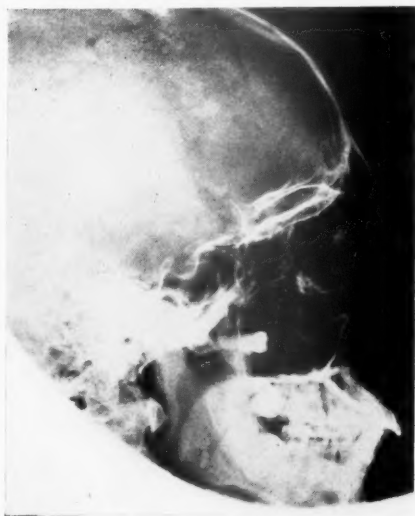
Roentgenogram of sinuses; lateral view.
